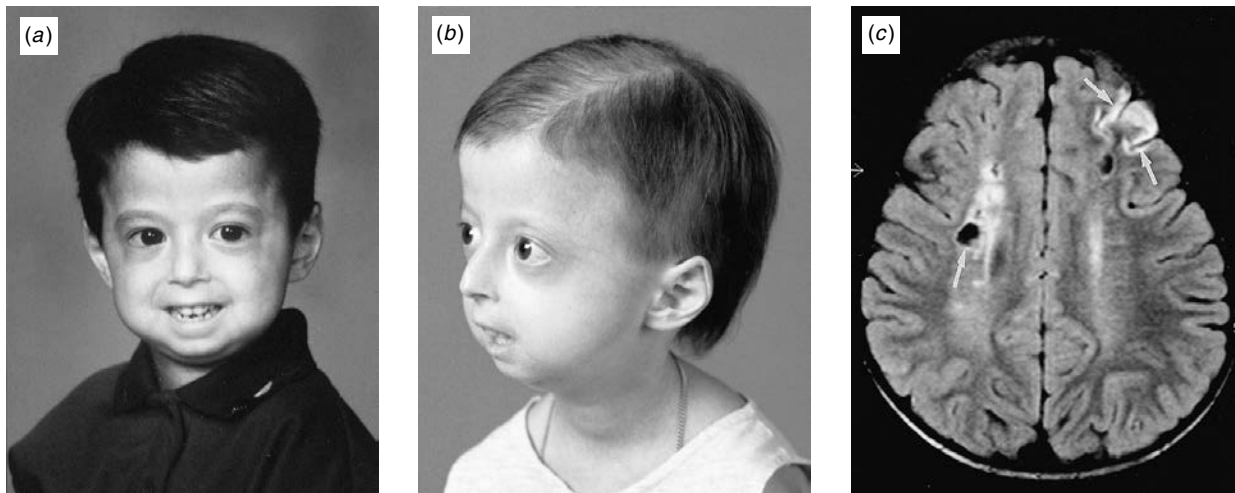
Premature aging in a young boy with multiple ischemic infarctions. (a) School portrait prior to the onset of symptoms. (b) Later photograph reveals hair loss, stooped posture, and loss of subcutaneous fat. (c) Magnetic resonance image shows multiple ischemic infarctions of different ages (arrows). (Reprinted from Miller & Roach, 2000, with permission.)
